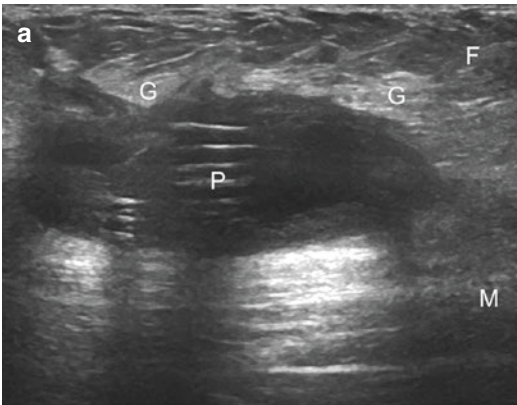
(a) Ultrasound performed 1 year after band insertion demonstrates normal appearances of the port, which lies deep in the subcutaneous fat (F) but superficial to the abdominal muscles (M). Reverberation artifact can be seen from the port components, as well as normal
